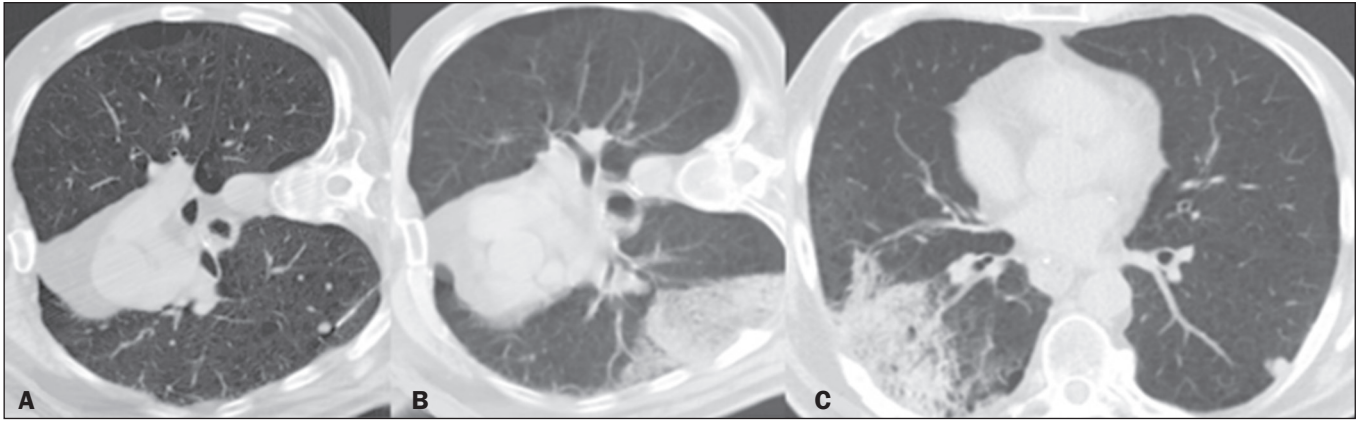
A: Pulmonary nodule with regular margins, measuring 4 mm, with needle insertion into the lung parenchyma. B: Alveolar hemorrhage after collection on immediate follow-up CT. C: Follow-up CT at three hours after the procedure, showing stabilization of the hemorrhage.
